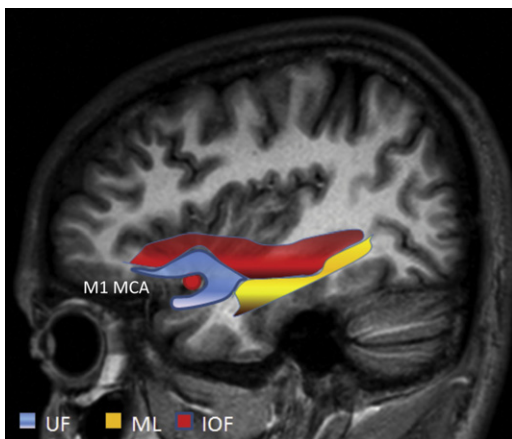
MR image showing uncinate fasciculus, inferior occipitofrontal fasciculus (IOF), and the Meyer loop fibers projected to the cortical surface. Note the looping of the uncinate fibers around the M1 middle cerebral artery (MCA).
